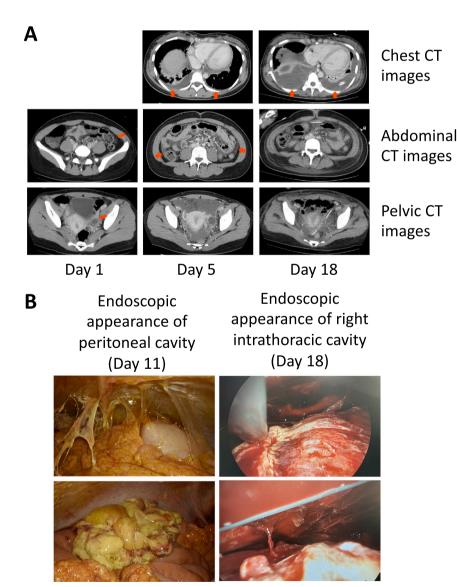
(A) Contrast-enhanced computed tomography (CT) images from the chest to pelvic cavity on hospitalization days 1, 5, and 18 and (B) endoscopic appearances of peritoneal and right intrathoracic cavities on hospitalization days 11 and 18. A left ovarian cyst and a localized thickened peritoneum of the left lower abdomen on the day 1 (arrows). Generalized thickened peritoneum, increased ascites, and bilateral pleural effusions on the day 5 (arrows). Increased bilateral pleural effusions on the day 18 (arrows).
